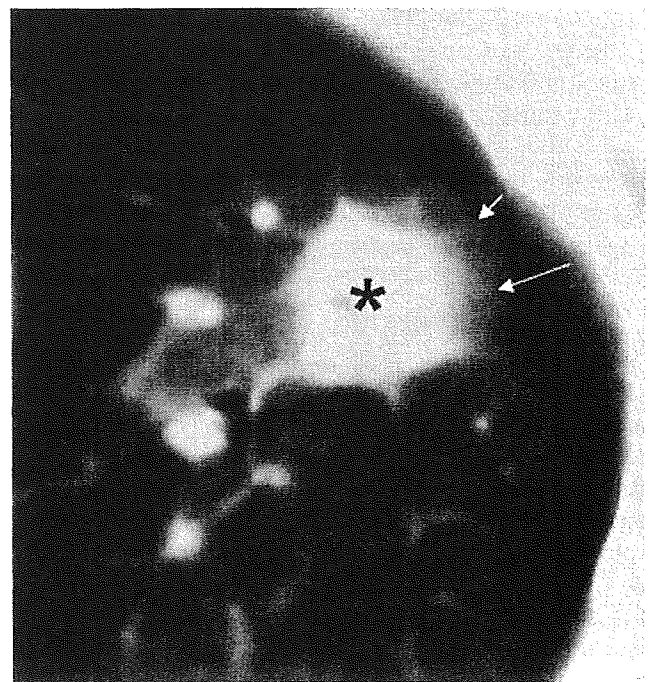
CT halo sign in IPA. The CT image of the lung demonstrates a halo sign in a patient with IPA and underlying hematological malignancy. The sign consists of two parts: first, a solid soft tissue macronodular core (≥ 1 cm) through which no pulmonary parenchyma is visible (*), and second, a ground-glass perimeter of intermediate density (arrows) through which the pulmonary parenchyma is still visible. Image obtained from Greene et al. (2007) with permission of the publisher.
